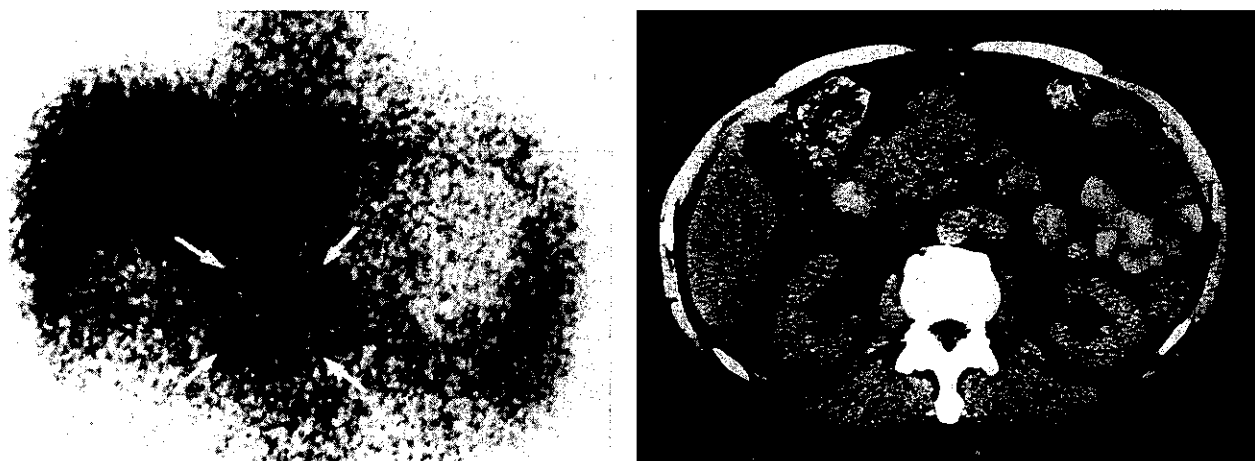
Anterior planar scintigram with $^{111}\text{In-Nd2}$ and plain abdominal CT scan in a case of true-positive RAID (patient 1 in Table I). The planar scintigram reveals specific accumulation of $^{111}\text{In-Nd2}$ at a site corresponding to the tumor lesion (arrow), which can be detected in the head and body of the pancreas in the CT scan, in addition to non-specific accumulation in the liver.
